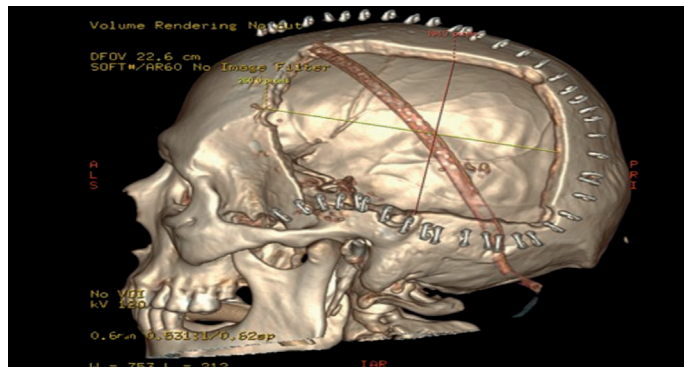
Three-dimensional reconstruction of postoperative brain computed tomography image showing the anteroposterior diameter and width of the craniectomy bone flap
